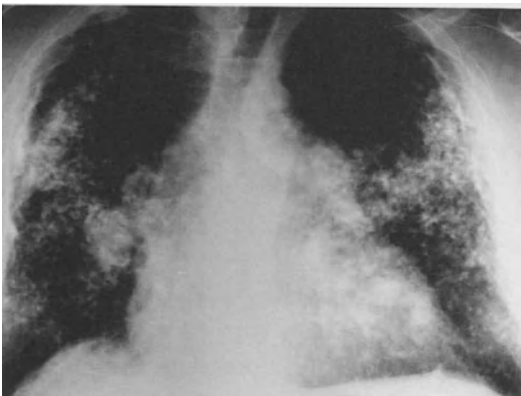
Chest X-ray in berylliosis showing diffuse pulmonary fibrosis of enlargement of the heart and pulmonary artery.
